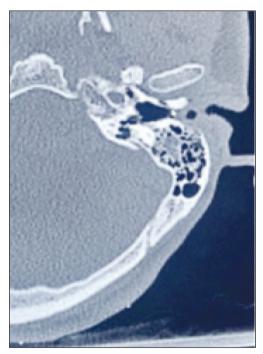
A linear fracture in the temporal bone on computed tomography.
